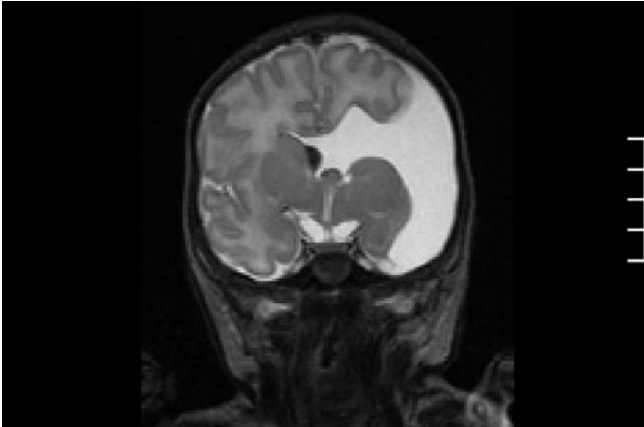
Coronal postnatal MRI demonstrating left sided open-lipped schizencephaly.
